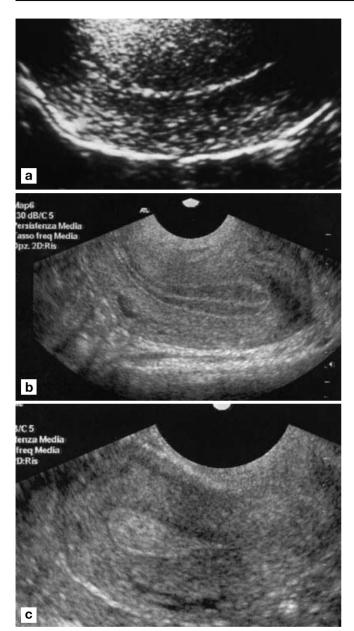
a-c Ultrasound monitoring of the uterine structure. a In the postmenstrual period the endometrium appears as a single echogenic central line. b In the proliferative phase, the endometrium gets thicker and assumes a structure made of three, alternate hyper-hypo-hyperechogenic lines. c The secretory phase is characterized by a thick, homogeneously hyperechoic, endometrial appearance
